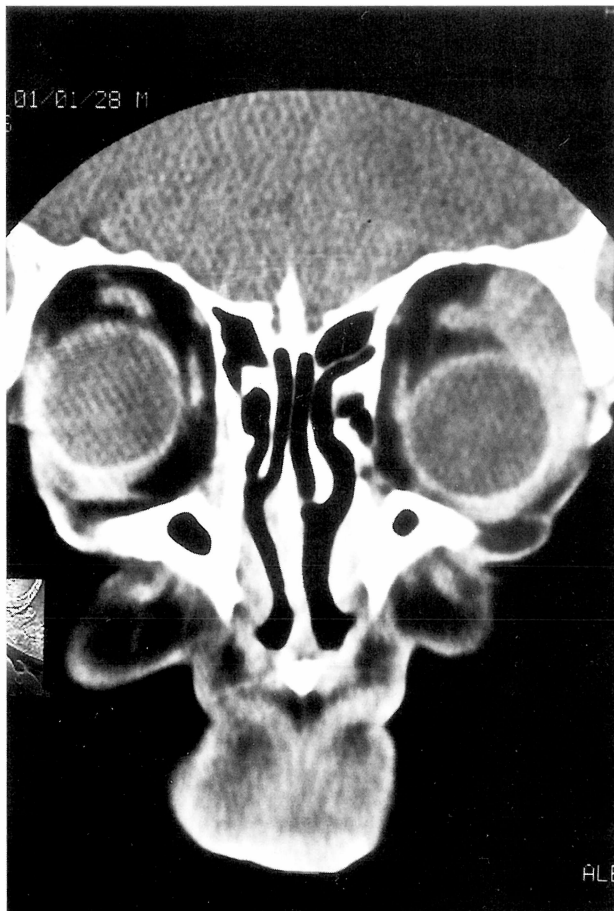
CT (coronal view). Unilateral homogeneous enhanced soft tissue mass, after i.v. administration.
